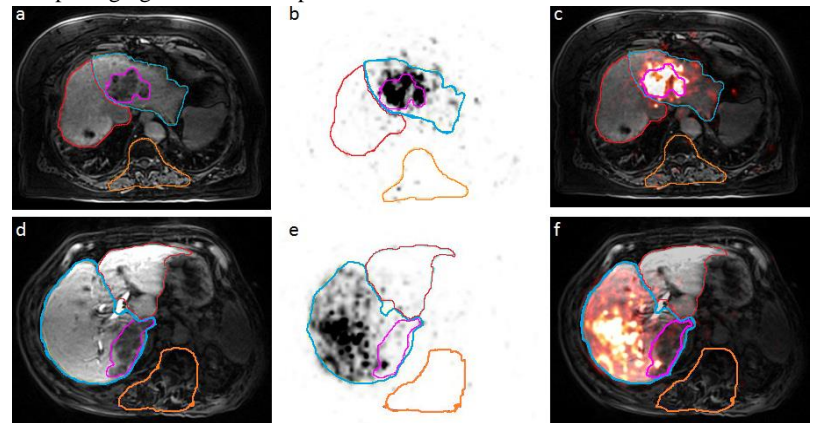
MRI (a, d), PET (b, e), and fused PET/MRI (c, f) images of two patients who underwent ⁹⁰Y radioembolization. Lesions (pink); treated lobe (blue); non-treated lobe (red); normal (orange). PET/MRI allows for simultaneous acquisition of both anatomical information (MRI) as well as localization information of ⁹⁰Y activity (PET). The first patient (top) exhibits a liver that received most of its ⁹⁰Y uptake within the tumor region (pink ROI). The second patient (bottom) exhibits a liver that did not receive most of its ⁹⁰Y uptake within the tumor region (pink ROI), but rather in the rest of the treated side of the liver (blue ROI).
